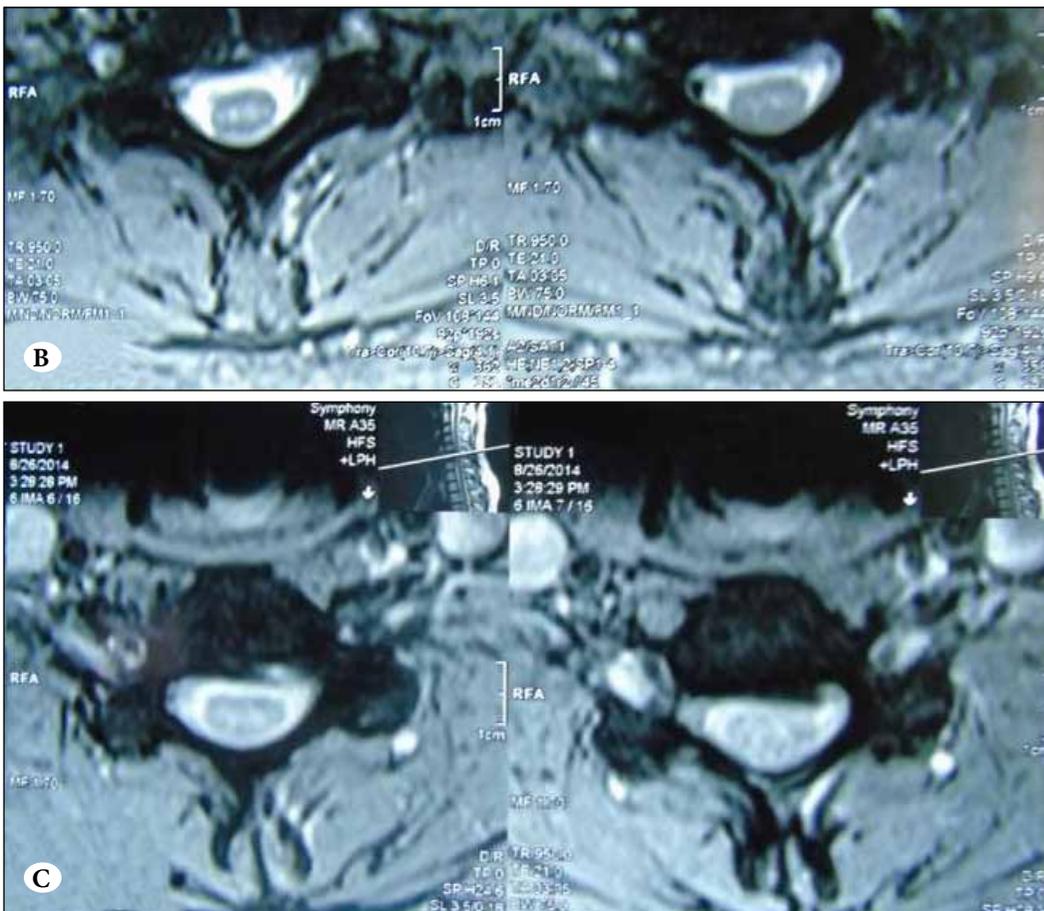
Cervical MRI; (A) Axial T2-weighted MRI at C5-C6 level showing left sided high intensity mass compatible with acute sequestered disc, near the left foramen. (B) T2-weighted at C6-C7 level demonstrate the disc near the corresponding foramen.
